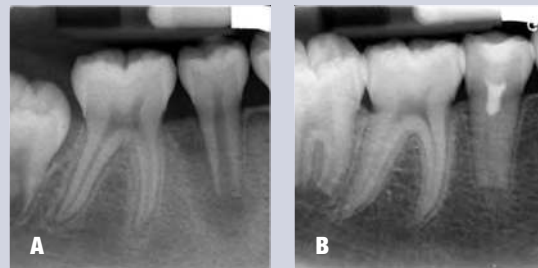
(A) Preoperative radiograph of tooth #29. B. 18-month review following regenerative endodontic treatment. Courtesy of Dr. Paul Brent, Portland, Ore.
